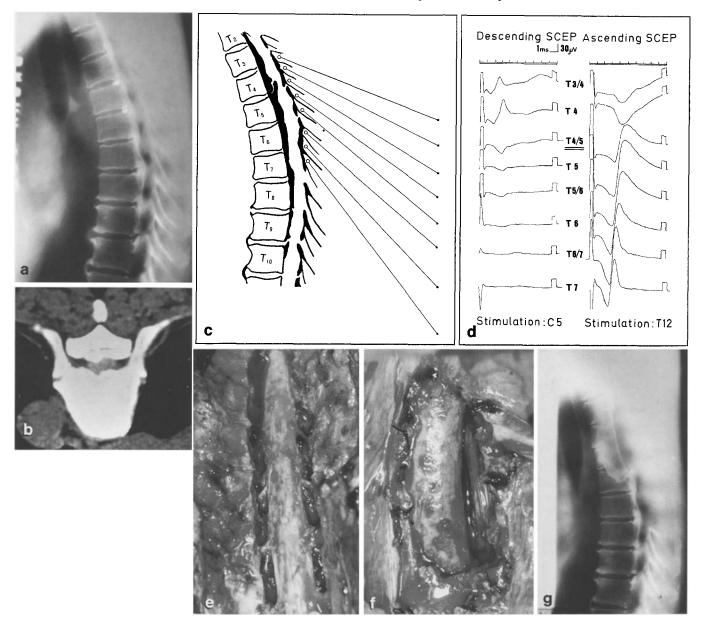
Case 8, female, 67 years. a Tomogram of thoracic spine; b CT scan at the level of T4; c scheme of OPLL (T2–10) and OYL (T2–12); d preoperative SCEP mapping. SCEP showing killed and potential at levels of T4, T5; e first step: wide laminectomy and guttar drilling; f second step: removal of OPLL and intervertebral body fusion; g postoperative tomogram (OPLL of T3–6 was removed and iliac bone was grafted)
